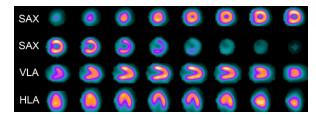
Single-photon emission computed tomographic myocardial stress perfusion images show no ischemia or myocardial scarring under exercise and rest conditions.
